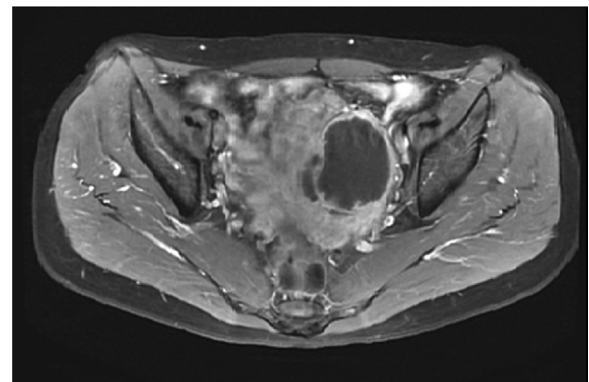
Pelvic contrast MRI T1-weighted image. Strong contrast effect noted in the tumor wall; low-signal cyst interior.
